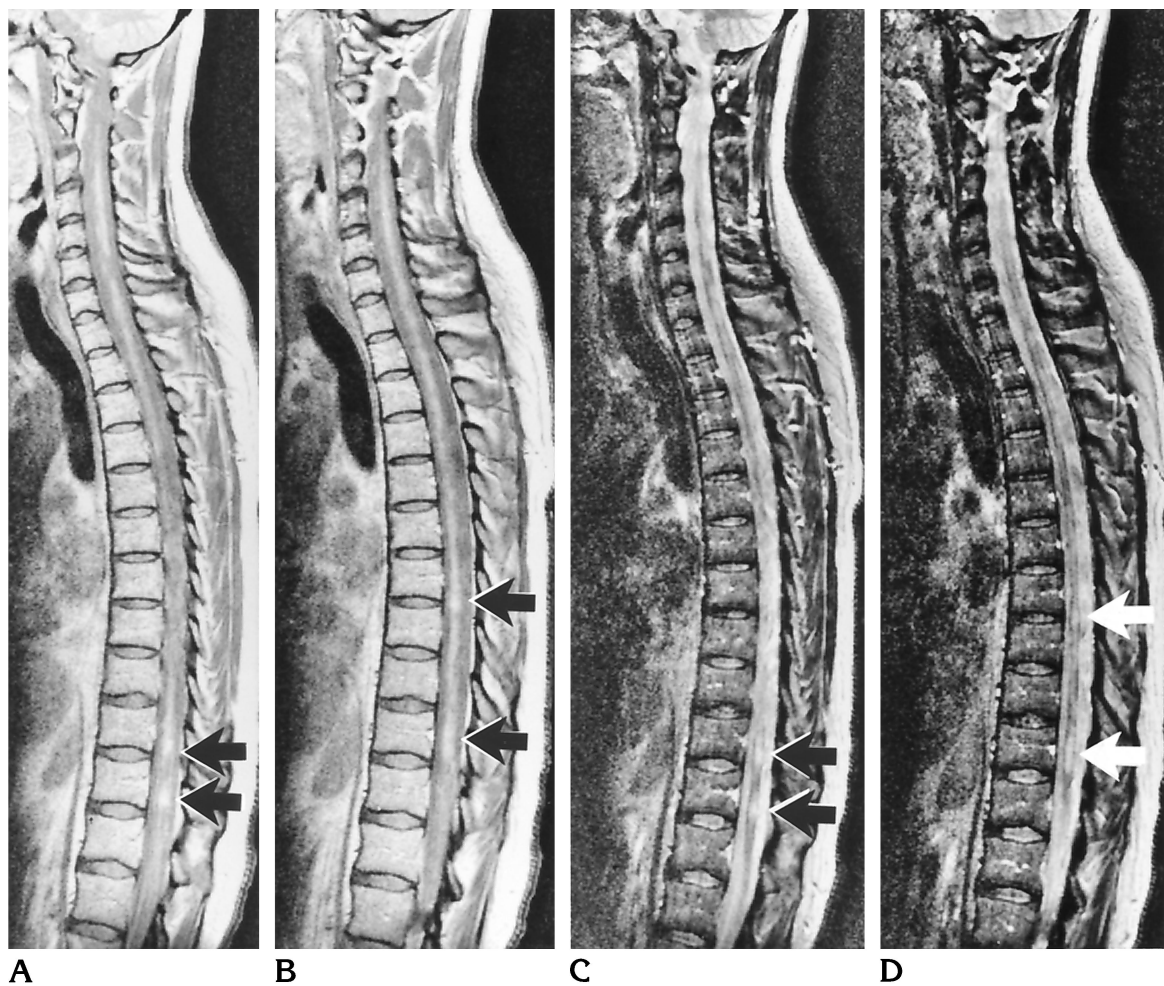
Type II MR finding. Sagittal proton density-weighted (A, B) and T2-weighted (C, D) MR images (2200/20,80/1) of a patient with secondary progressive MS show multiple focal lesions (arrows), especially on the T2-weighted images. On the proton density-weighted images, the spinal cord appears diffusely involved, including areas in which there are no focal lesions on the corresponding T2-weighted image.
